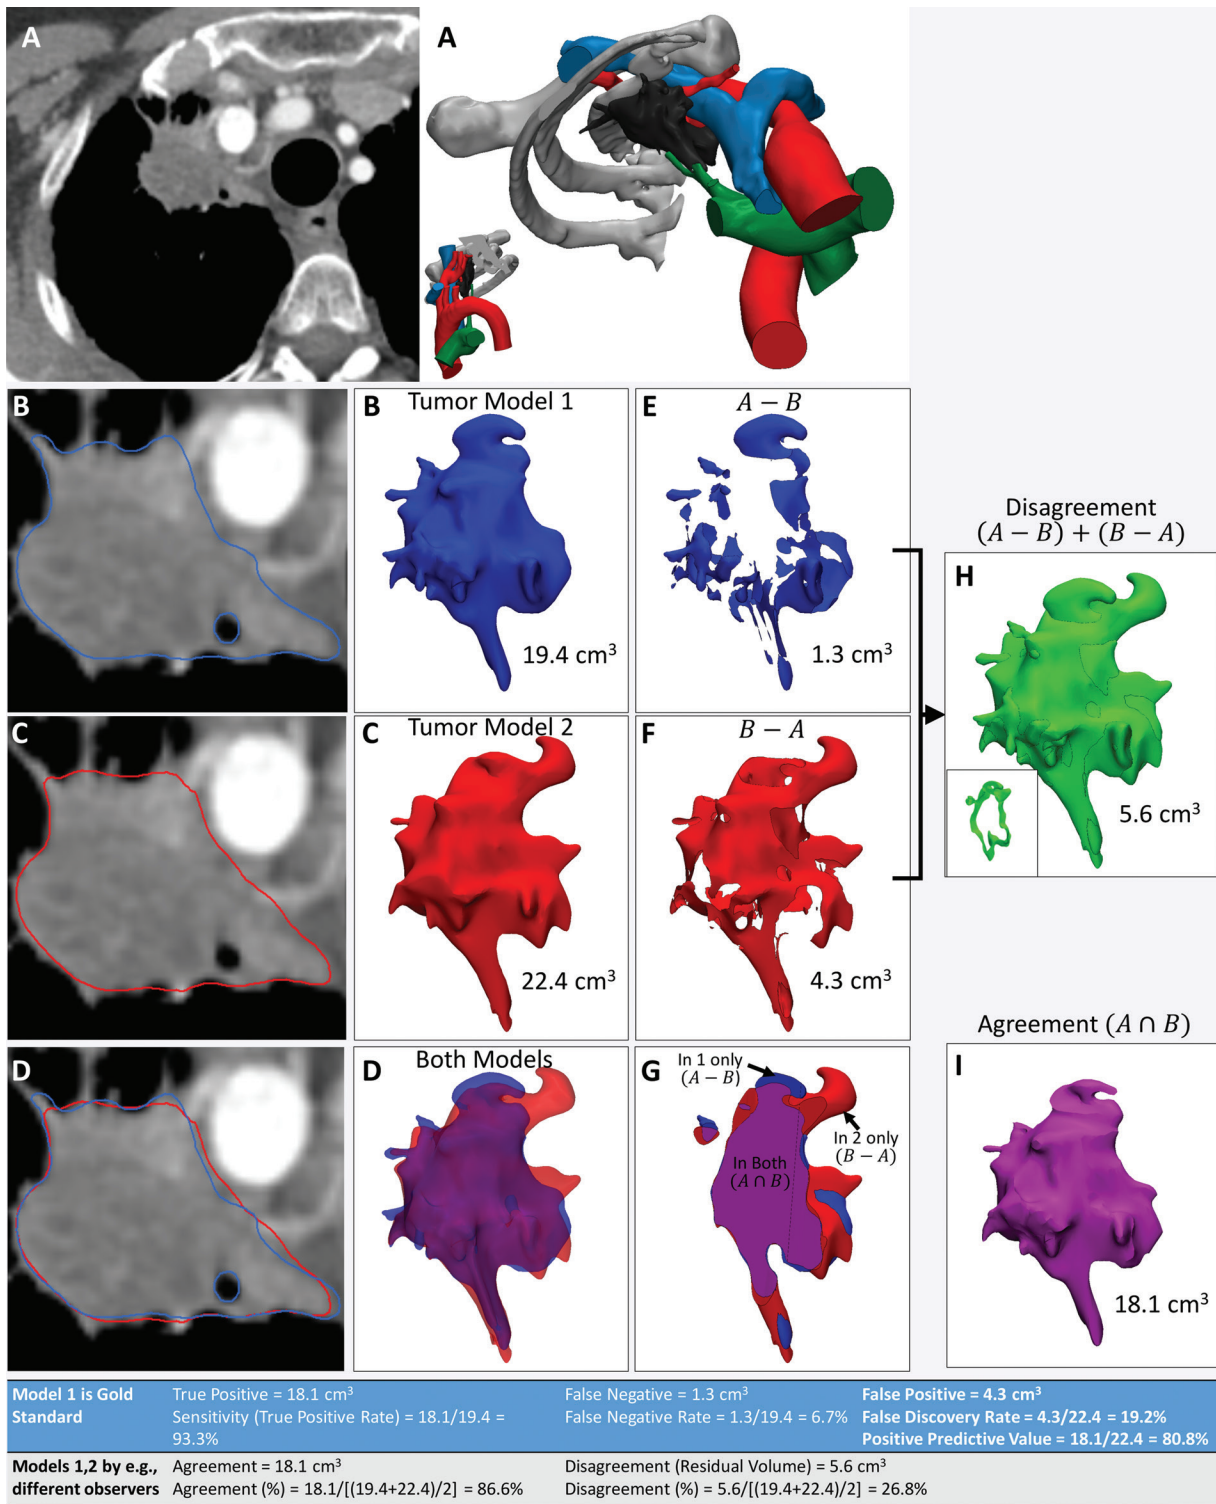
Use of agreement and disagreement operations to compare different segmentation methods. *A*, Example assessment of similarities and differences in lung apex tumor models (right) derived from axial contrast-enhanced CT images (left). *B*, *C*, The tumor segmented by two independent readers (*B* and *C*, respectively) and seen on axial CT images (left) and 3D visualization models (right) is qualitatively different. *D*, Both models, seen superimposed on the axial CT image (left) and semitransparent 3D visualization models (right), are cut through the model in *G*. *E*, *F*, Morphologic operations are used to define differences quantitatively. For example, the model in *E*, shows the tissue considered by one reader to be in the model, in disagreement with the interpretation of the second reader. The model in *F*, shows the tissue considered by the second reader to be in the model, in disagreement with the interpretation of the first reader. *H*, *I*, Disagreement, *H*, and agreement, *I*, can be used to define diagnostic accuracy or reproducibility parameters (Table at bottom). The inset in *H*, shows a section through the volume that is empty where there is agreement.
